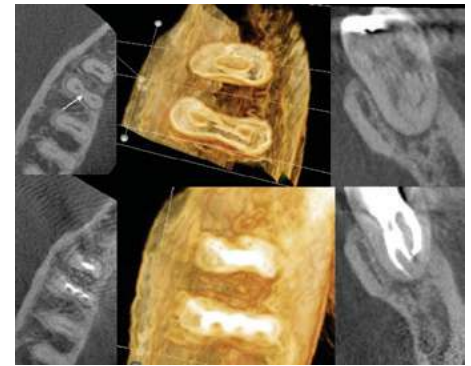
An example of using CBCT imaging for identification of complex tooth anatomy in a mandibular first molar. CBCT axial and coronal views (top) demonstrating the presence of a middle mesial canal (arrow). One-year recall CBCT axial and coronal views (bottom) demonstrating the obturation of the complex mesial canal anatomy.
